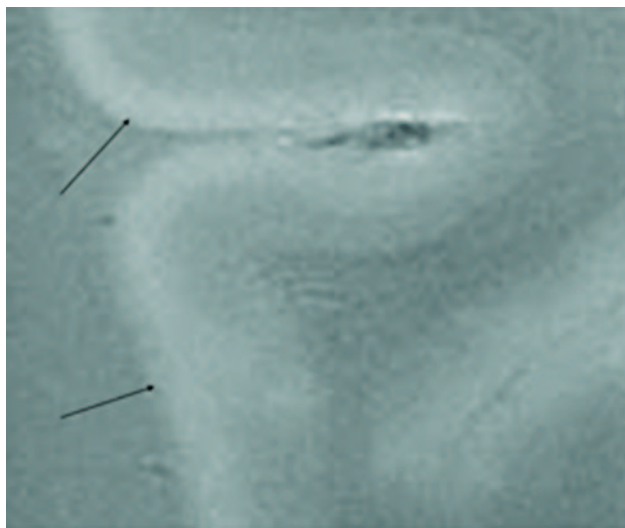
SE T2-weighted image, TR = 750 ms, TE = 20 ms, FOV = 15 cm, matrix = 1024 × 1024, and section thickness = 1 mm. Type 3 cortical lesions. Bandlike areas of demyelination along the outer cortical layers spanning adjacent gyri result in extensive involvement of the cortex.
